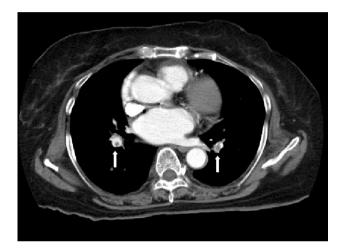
Multidetector CT pulmonary arteriography showed a typical filling defect in the pulmonary arteries of this 71-year-old female; this patient had left-side total knee arthroplasty. Emboli are visible in the left and right pulmonary arteries of the lower lobes (*white arrows*)
